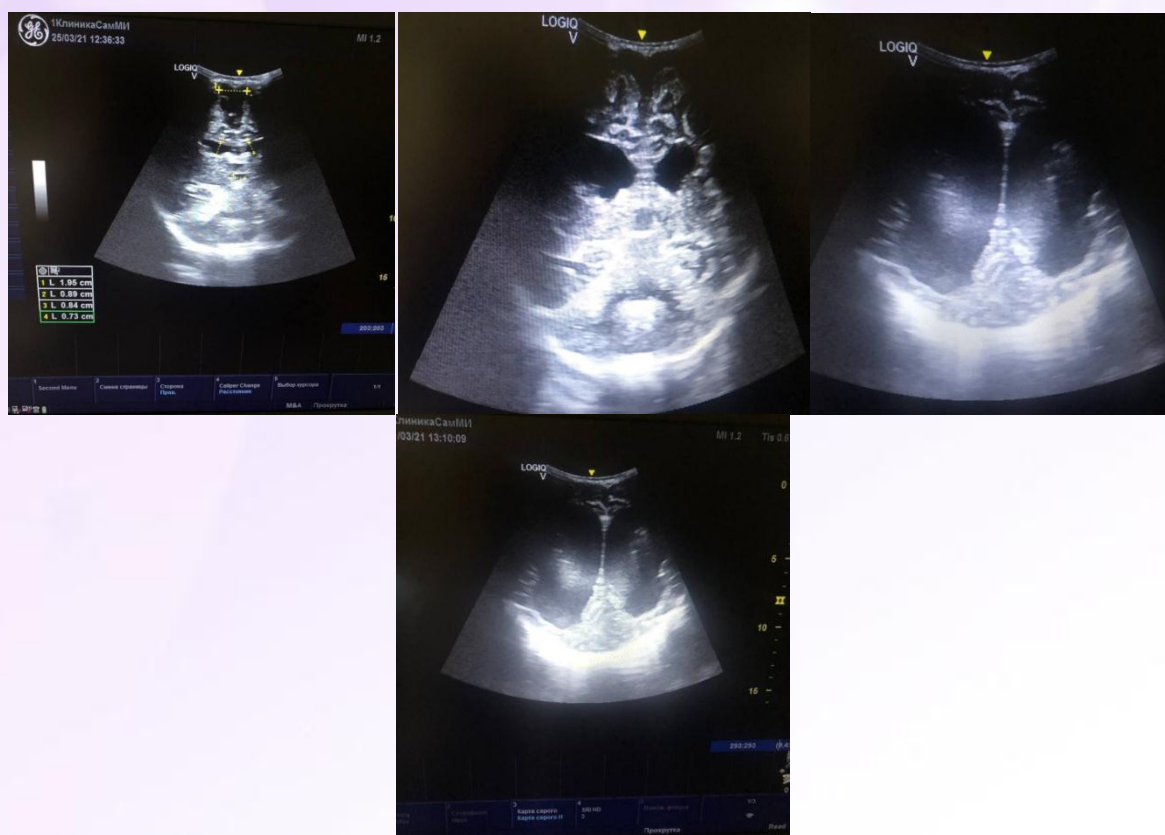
Neurosonography of a 3-month-old patient
